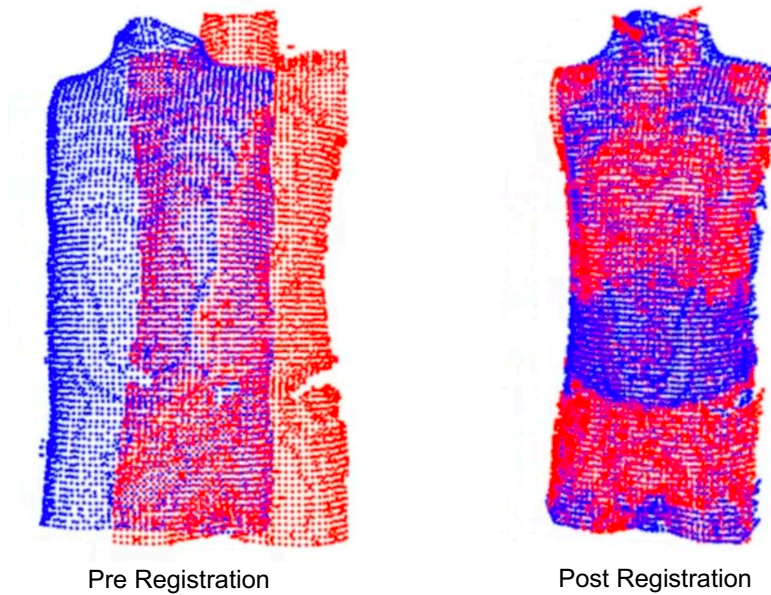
Feature-based registration is used to match two point sets. In blue a point cloud extracted from a full-body MRI, in red one obtained from a 3D vision system. The two point sets undergo a deformable registration, its result is shown on the right side.
